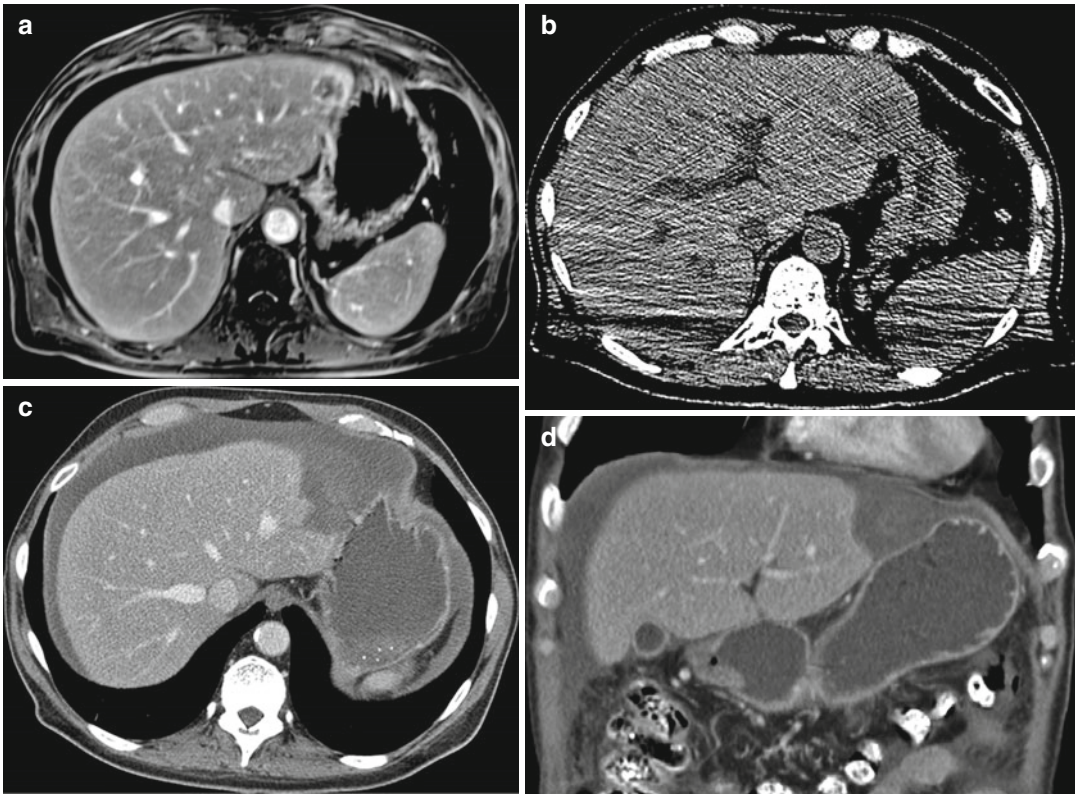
Axial contrast-enhanced T1-weighted MR image shows a metastasis in liver segment III in a patient treated with peritoneal dialysis for renal insufficiency (a). CT immediately before percutaneous placement of the microwave antenna depicts a slight increase in size of the target tumor, which is now in contact with the stomach
